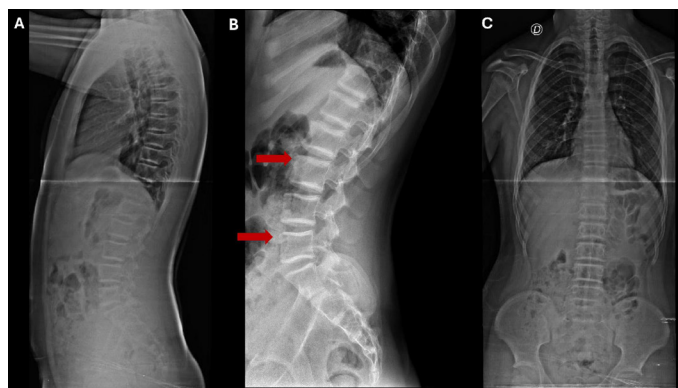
Lateral spine X-ray images of Patient #2 (Panels A and B) prior to treatment show the following findings. (A) Thoracic spine: generalized decrease in bone mineral density. A moderate anterior wedge compression fracture is evident at the level of T9 (arrow). (B) Lumbar spine: diffuse reduction in vertebral radiopacity, also suggestive of decreased bone mineral content. The L4 vertebral body demonstrates a mild reduction in anterior height with a subtle wedge-shaped deformity suggestive of a compression fracture (arrowhead). (C) Anteroposterior radiograph of the thoracolumbar spine showing mild right-convex thoracic scoliosis with compensatory lumbar curvature. Note the subtle anterior height loss and wedge-shaped deformity of the L4 vertebral body (red ellipse)
